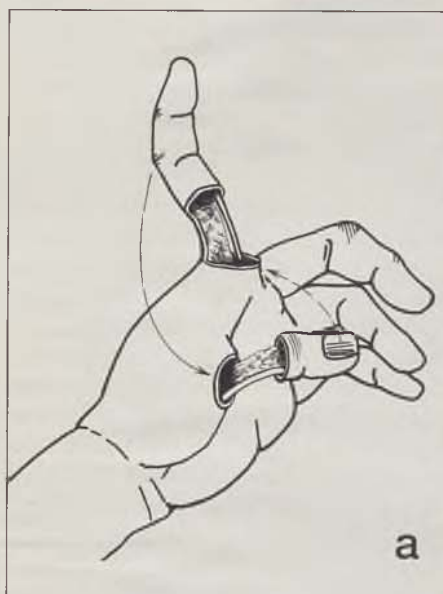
Scheme of the transposition of the index finger to the site of the thumb and simultaneously the hypoplastic thumb to the site of the index finger (a), final position of the fingers after the double-transposition (b), X-ray picture 1 year after surgery (c).
